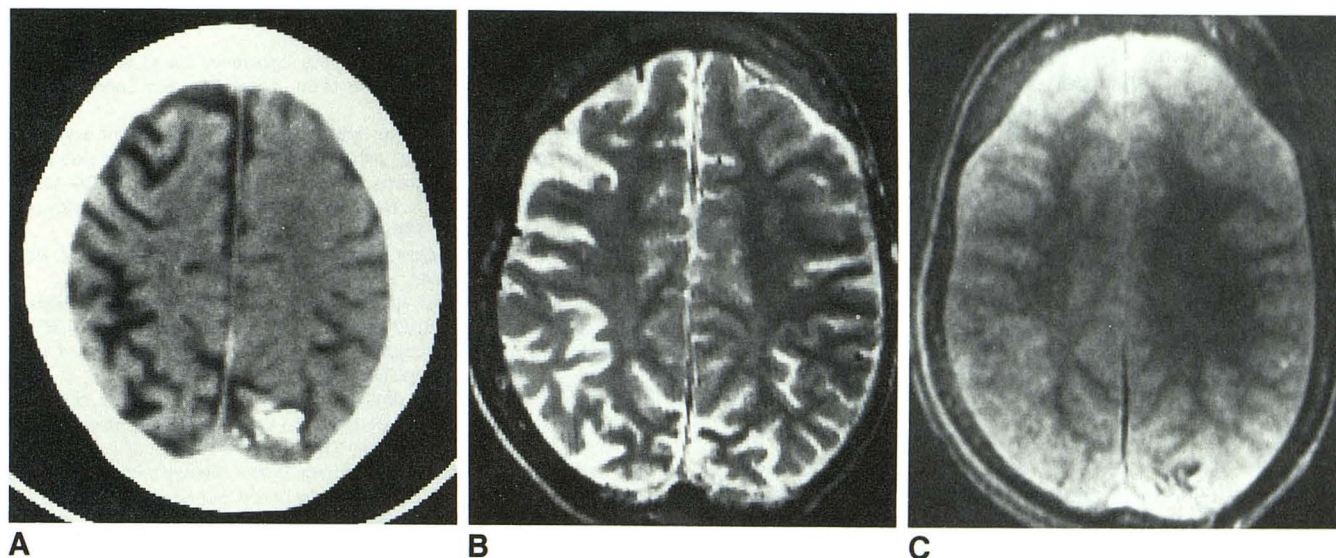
A, Unenhanced CT scan shows bilateral hemispheric atrophy and left parietal gyral calcifications. B, T2-weighted image (2010/120) at same level shows bilateral hemispheric atrophy but fails to demonstrate gyral calcification. C, Gradient-echo sequence (200/13/10°) reveals that gyral calcification is visualized because of its magnetic susceptibility.
